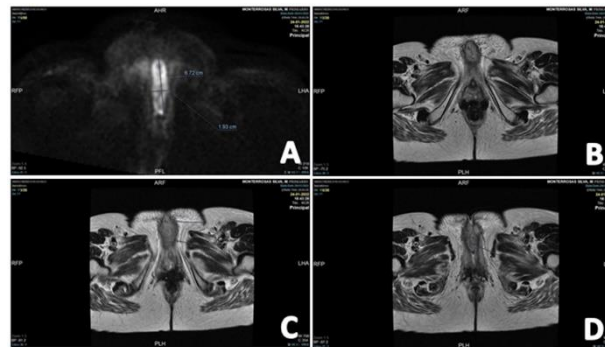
(A-D): MRI of pelvis with contrast irregular thickening of the vulva in its mid and anterior portion, with enhancement after intravenous contrast administration.
